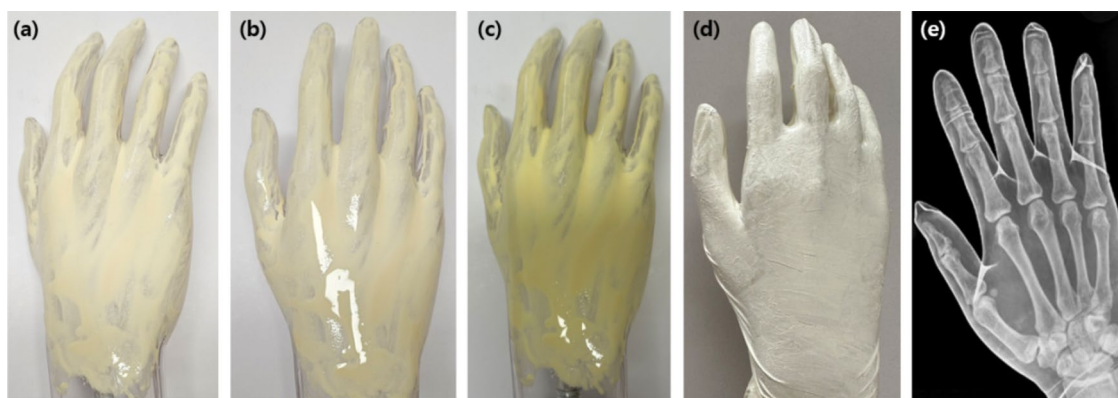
Verification of the dispersion effect in the process of radiation-reducing cream production. (a) 10 wt% barium sulfate, (b) 10 wt% bismuth oxide, (c) 10 wt% ytterbium oxide, (d) 25 wt% barium sulfate on a surgical glove, (e) X-ray image (40 kVp, 5 mAs) of (d).
